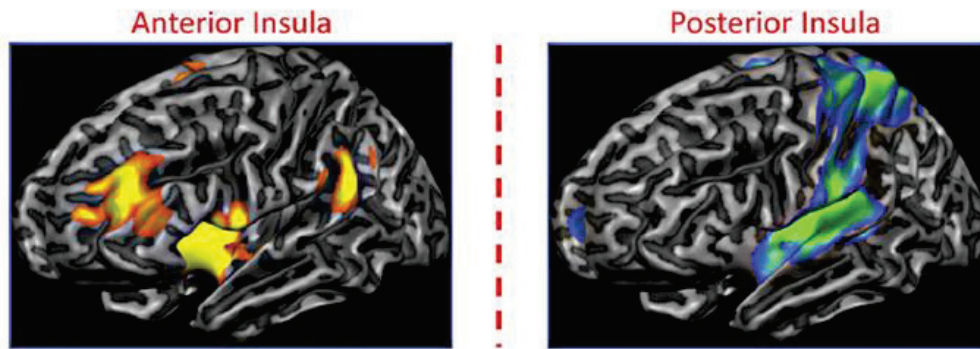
25: Anterior and posterior insular connectivity pattern as proven by resting stat MRI (Cauda et al., 2011)
